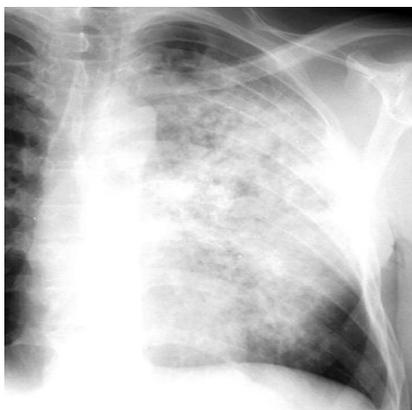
Parenchymal primary tuberculosis in an adult. Radiograph of the left lung demonstrates extensive upper lobe and lingular consolidation.
